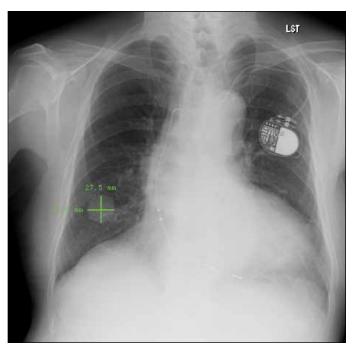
Chest radiography showed an approximate 3-cm mass lesion in the right lower lung and left ventricular enlargement (cardiothoracic ratio, 69.1%).
